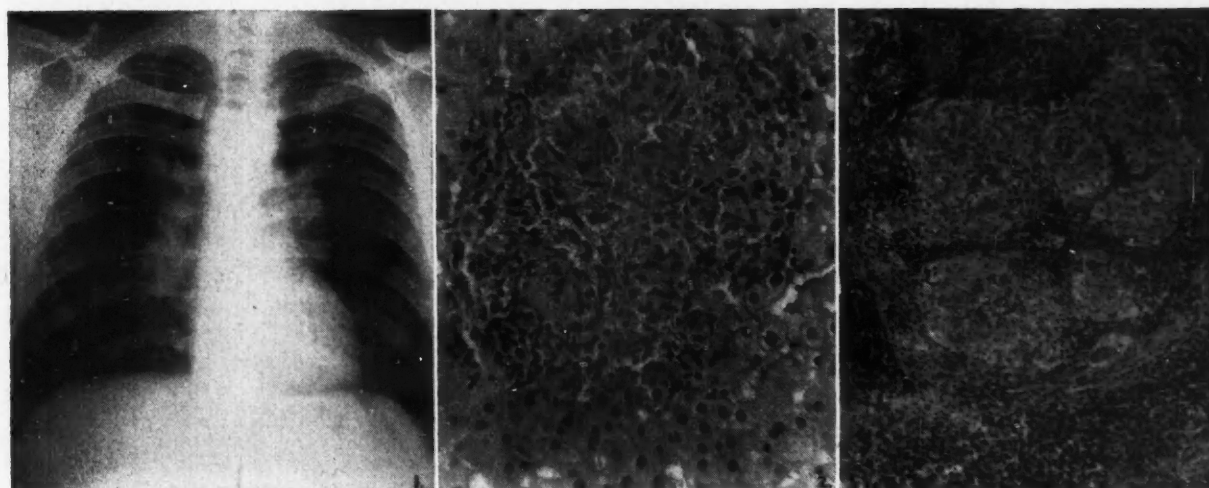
(Case 1).—X-ray showing hilar lymphadenopathy. Fig. 2. (Case 1).—Liver biopsy, hæmatoxylin and eosin; x430, showing a discrete granulomatous lesion. Fig. 3. (Case 1).—Axillary lymph node; hæmatoxylin and eosin; x100, showing granulomatous lesions.
